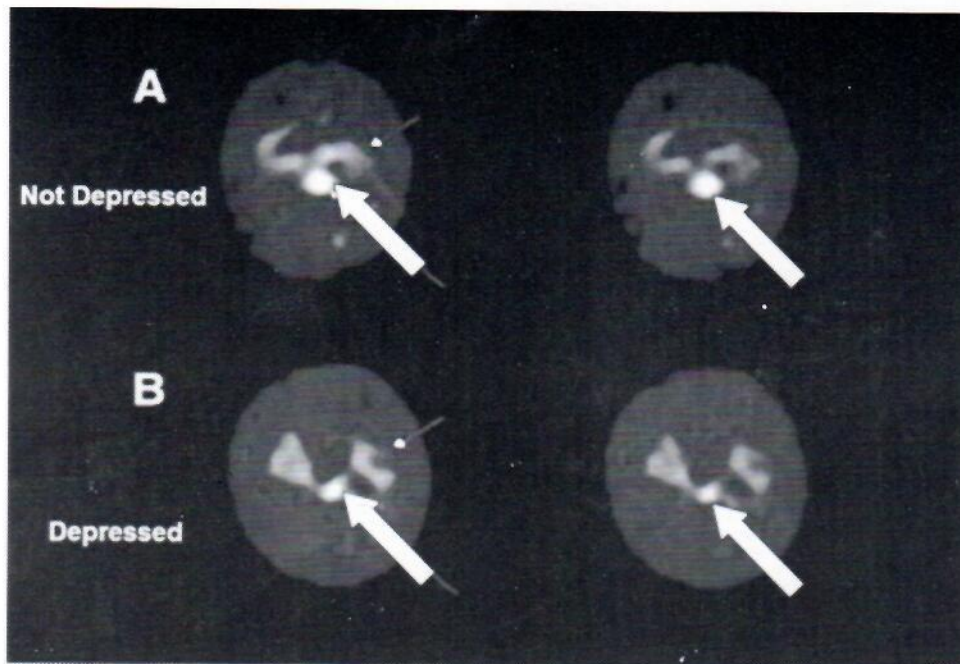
Axial SPECT functional images showing a control subject (A) and a depressed subject (B). Long arrows point to midbrain uptake, which is markedly less in depressed subject than in control subject.
